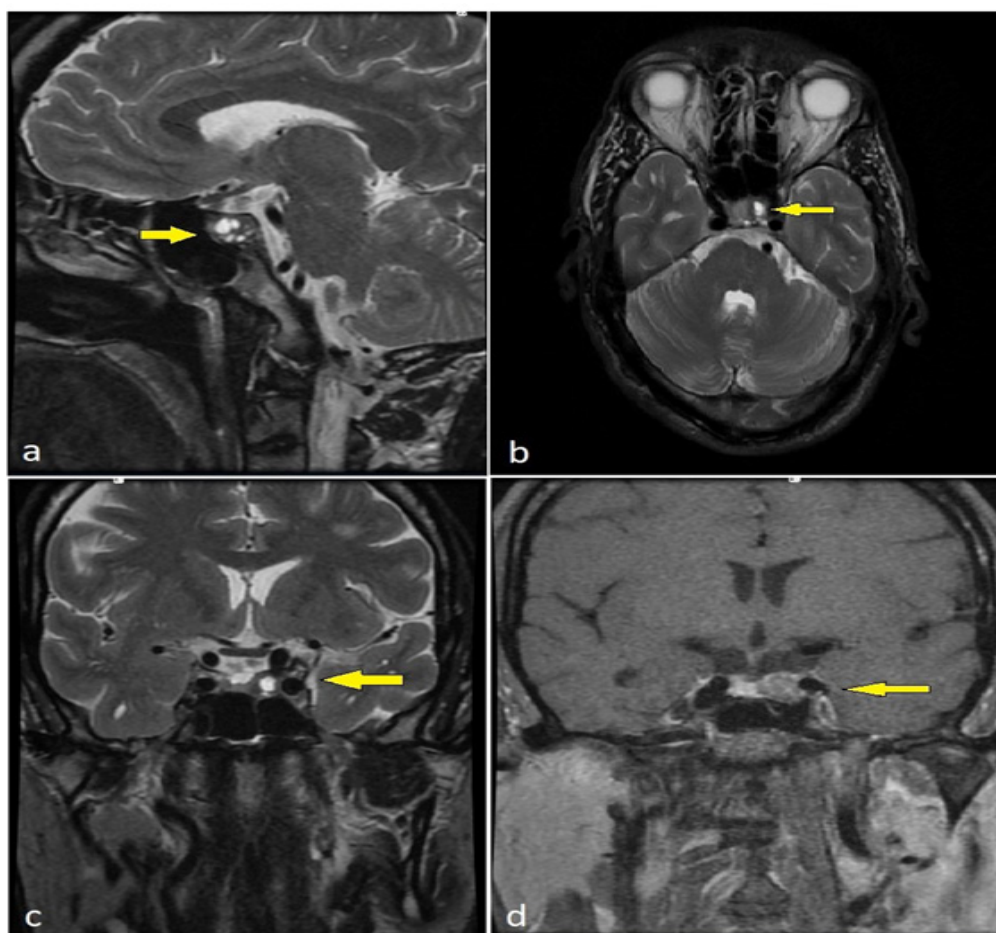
MRI brain and pituitary with contrast showing a bulky left lobe of the anterior pituitary gland with a small nodular lesion measuring 9.4x8.7 mm, causing a slight deviation of infundibulum towards the right. a: sagittal T2, b: axial T2, c: coronal T2, d: coronal post-contrast enhancement in the dynamic phase suggestive of pituitary microadenoma with cystic changes.
